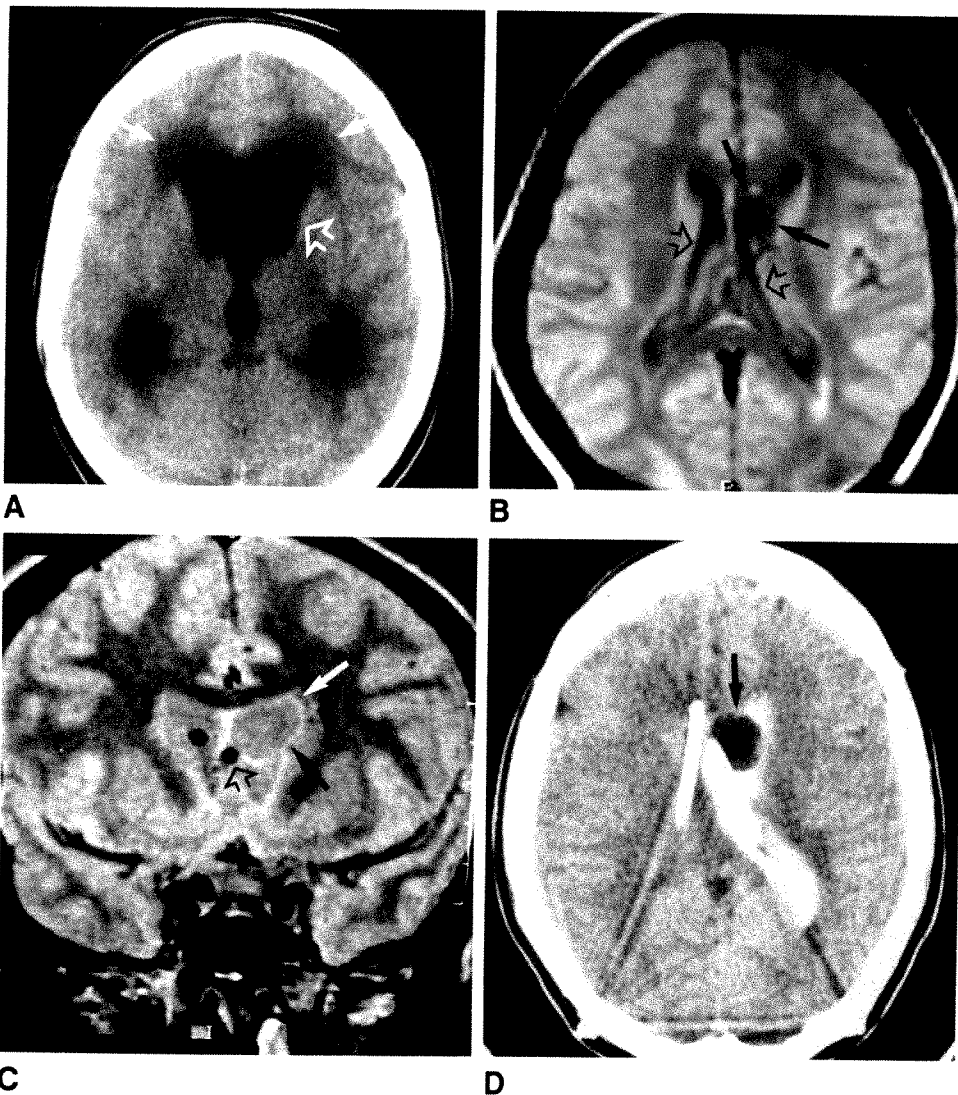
A, Nonenhanced brain CT scan shows third and lateral ventricular dilation as well as periventricular low attenuation (solid arrows) consistent with hydrocephalus with transependymal CSF flow. Frontal horn dilation is slightly more prominent on left side (open arrow).
